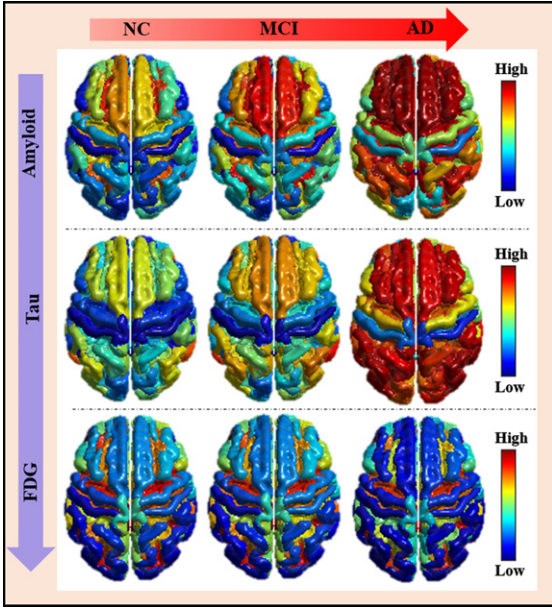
Regional SUVR level of amyloid, tau, and FDG. On the first two rows of the image, as the disease becomes more severe (NC→MCI→AD), the mean level of amyloid and tau in the corresponding brain areas shows an overall upward trend. The result for FDG in the last row is exactly opposite that of the first two biomarkers, which is in line with existing research.
